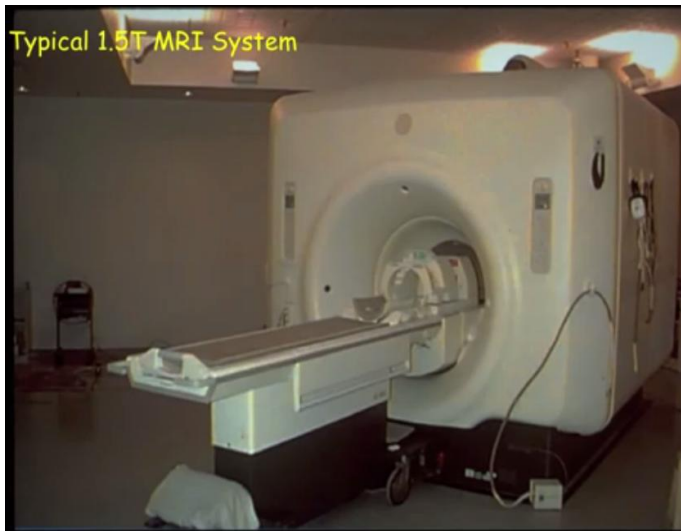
Medical imaging evolving over time, x-ray, CT, Ultra sound and MRI*
